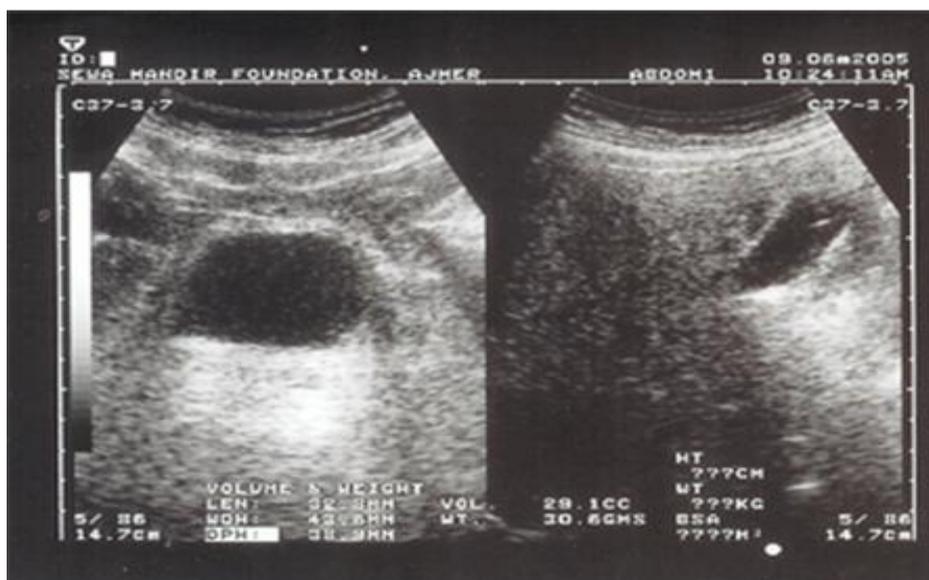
Sonography report before treatment (09.06.2005) showing Prostate enlargement with homogenous echo texture measuring 33mm x 44mm x 39mm in size and weight 30.6 gms. Prostate volume is 29.1 cc
